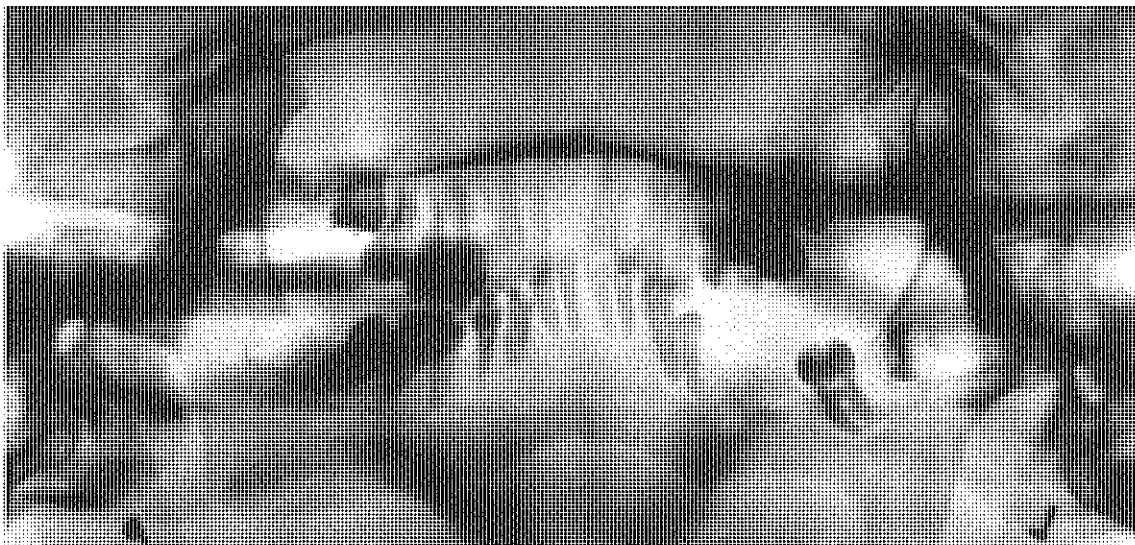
The panoramatic postero-anterior radiograph of the set of teeth in the skull with the bilateral ankylosis of the temporomandibular joints.
